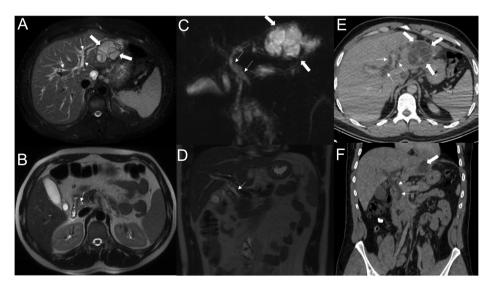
Fifty-four-year-old male with Gharbi type 3 hydatid cyst lesion in the left lobe of the liver with 6-day epigastric stomach pain and dyspeptic symptoms. (A, B) Axial/coronal T2-weighted fast spin echo magnetic resonance images demonstrate a type 3 hydatid cyst lesion (thick arrows). The common and main hepatic bile ducts contain hypointense membranous structures connected to hydatid cysts and are dilated. (C) Axial abdominal contrast-enhanced computed tomography scan shows a type 3 hydatid cyst (thick arrows) and a fistulous connection between it and one of the intrahepatic bile ducts (thin arrow). (D) Coronal magnetic resonance cholangiopancreatography image shows a type 3 hydatid cyst lesion (thick arrows). There is also bile duct dilatation and hypointense membranous structures caused by hydatid cysts in the common and main hepatic bile ducts (thin arrows). (E, F) Grayscale ultrasound (US) and color Doppler US images show semi-solid structures with uneven heterogeneous supply and no blood supply in the main hepatic bile duct in (thick arrows).
